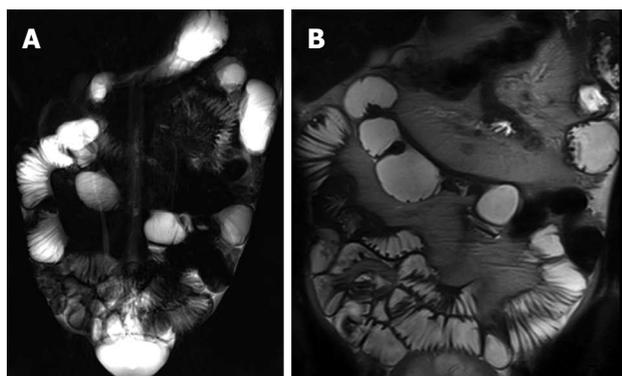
Coronal thick-slab HASTE (A) and coronal T2-weighted (B) images show pseudosacculations produced by asymmetric thickening of the ileal mesenteric border.
